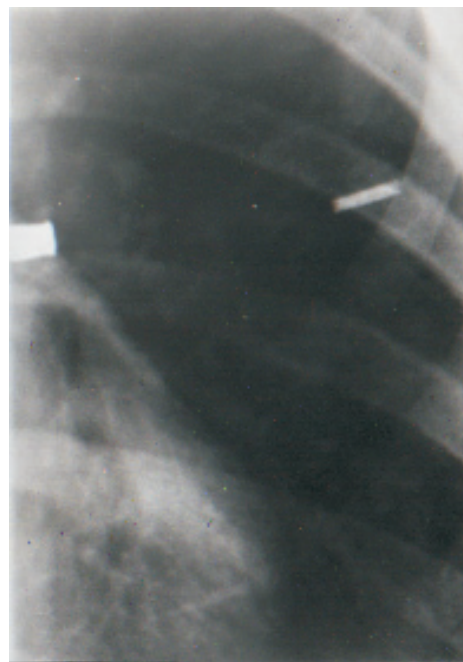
X-ray image of laser Doppler flow probe inserted into small bronchus.
